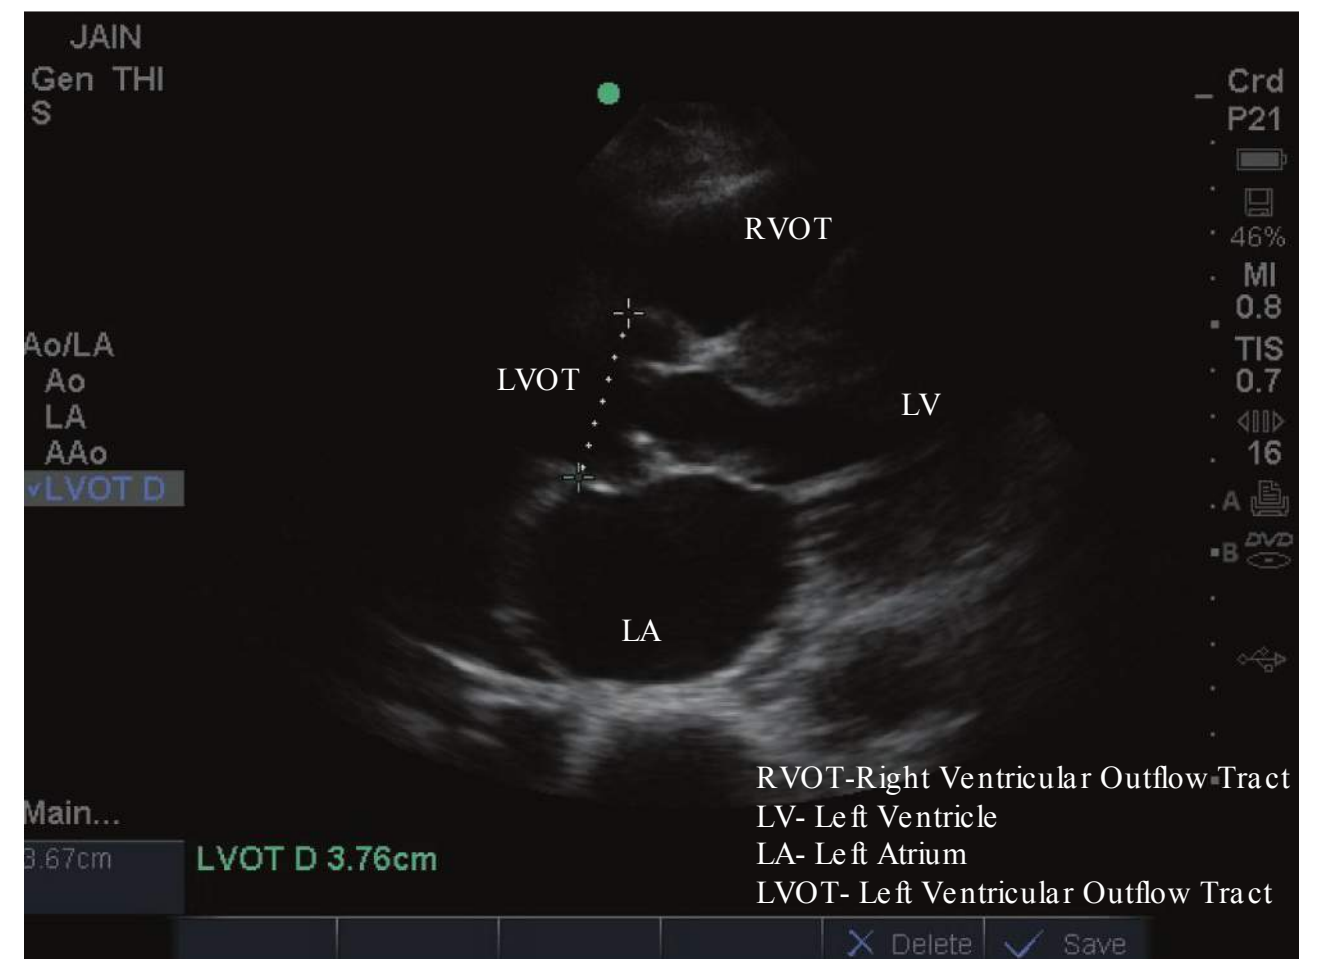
B-mode echocardiography of parasternal long window for left ventricular outflow tract diameter (LVOT D). This measurement can be used to calculate cardiac output.
